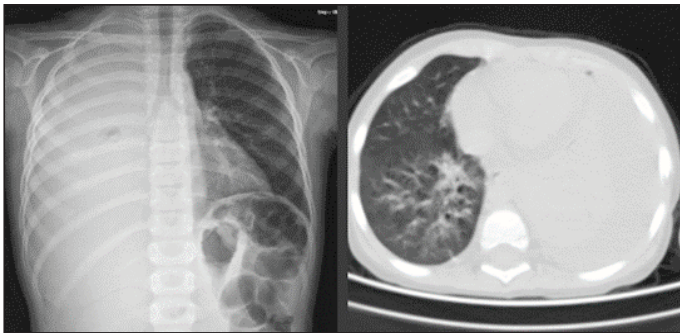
X-ray and thorax CT Images of a 10-year-old boy with pleural effusion.
